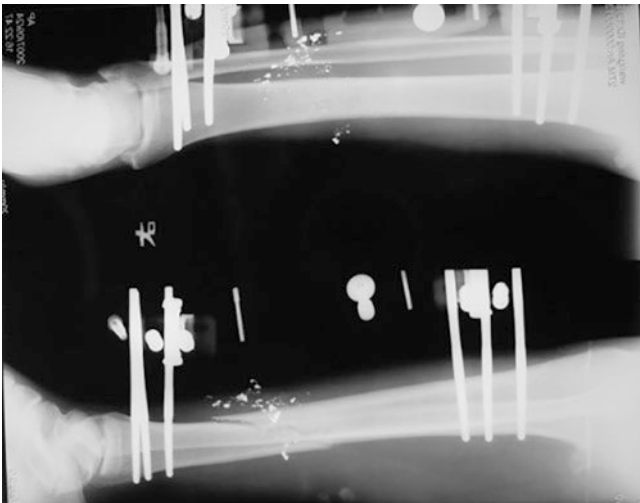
X-ray scan primary debridement and suture and primary internal fixation of fractures in high-altitude explosion blast injuries (image by Yin Zuoming)
